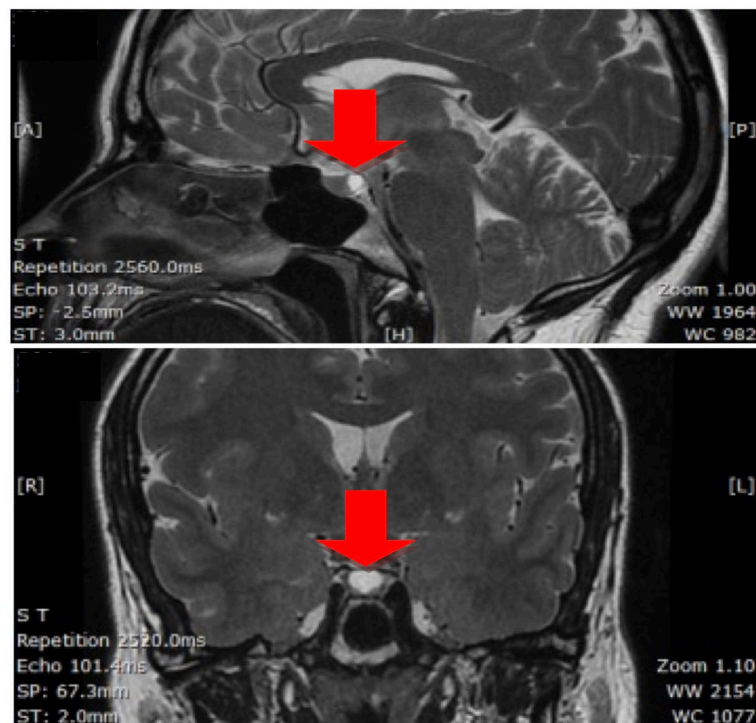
Magnetic resonance imaging after two years of diagnosis.
